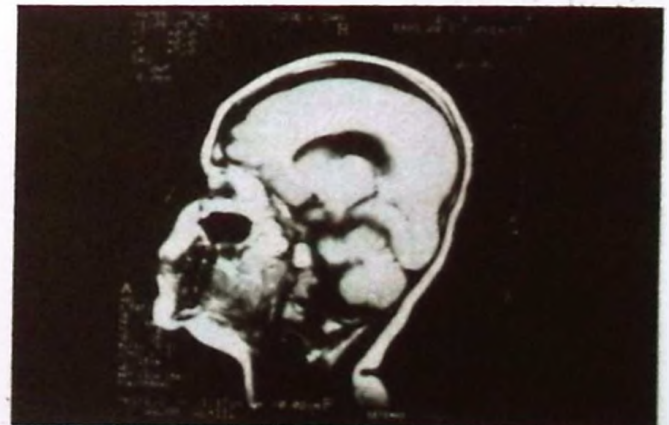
Cranial MRI of Case 16 (grade 4 lissencephaly, axial view).
